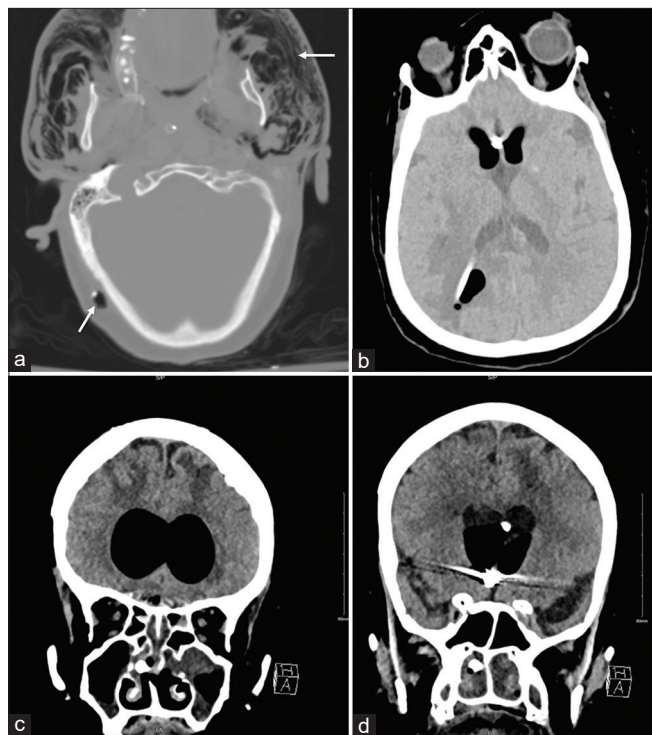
Axial CT scan of the brain showing diffuse subcutaneous emphysema (a) reaching the face with air around the VP shunt distal catheter [arrows], (b) extending through the burr hole to the ventricles causing pneumocephalus, and (c and d) coronal CT scan of the brain showing intact skull base with no evidence of fractures.
